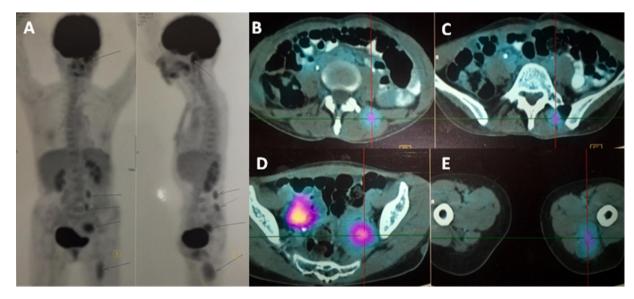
PET-CT. Coronal, sagittal and axial sections showing metastatic lesions (arrows) at paravertebral (A–C), pelvic (A and D) and left thigh levels (A and E) with increased metabolism of 5-fluorodeoxyglucose.
